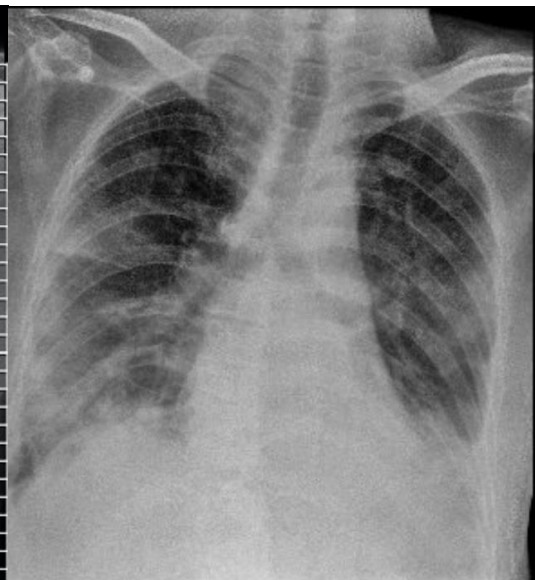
Chest X-Ray (5th Day)
